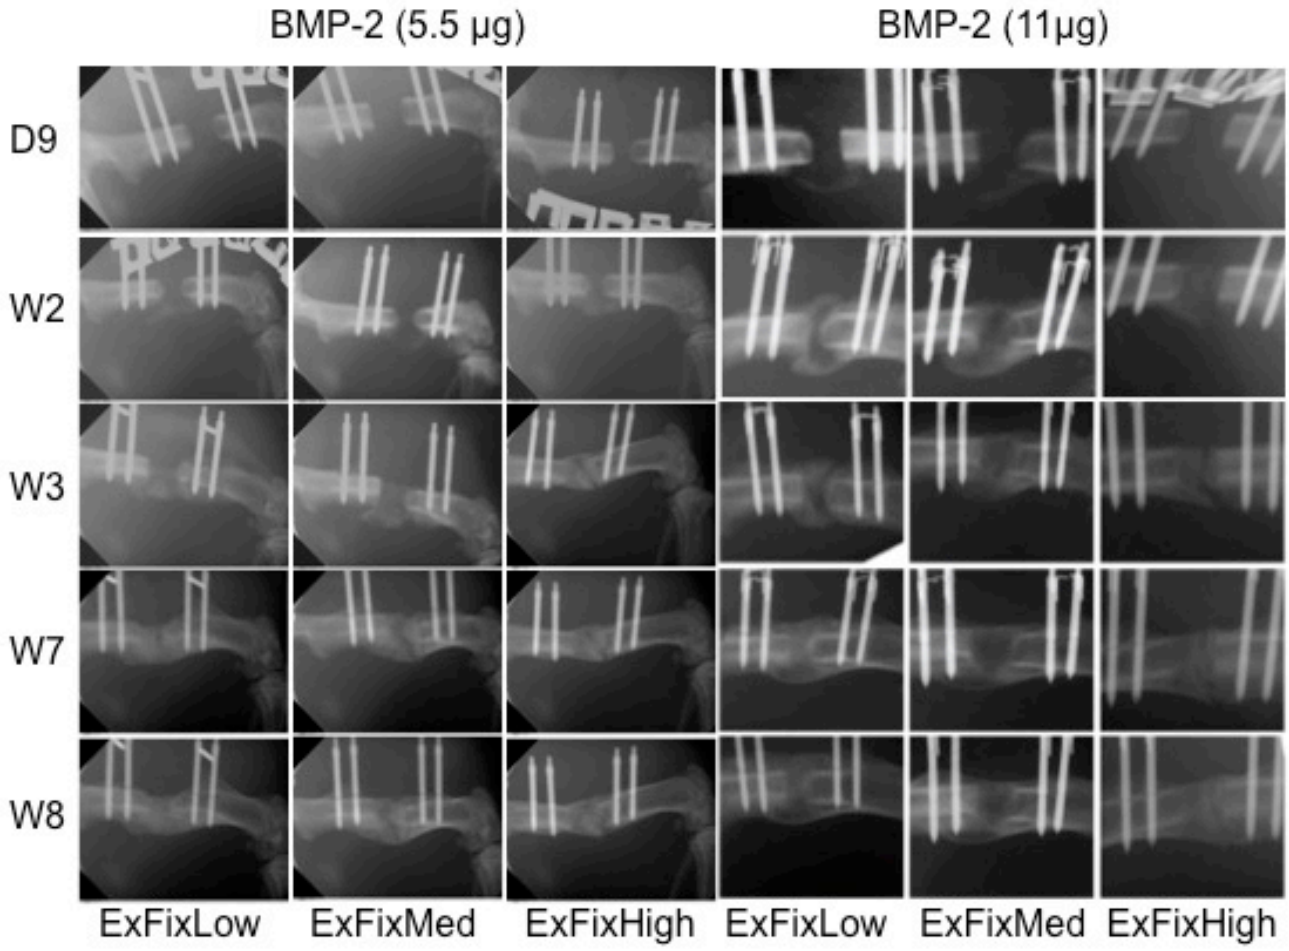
X-ray images of defects healed under conditions of low (*ExFixLow*), medium (*ExFixMed*) and high (*ExFixHigh*) stiffness using 11 μ g or 5.5 μ g BMP-2
